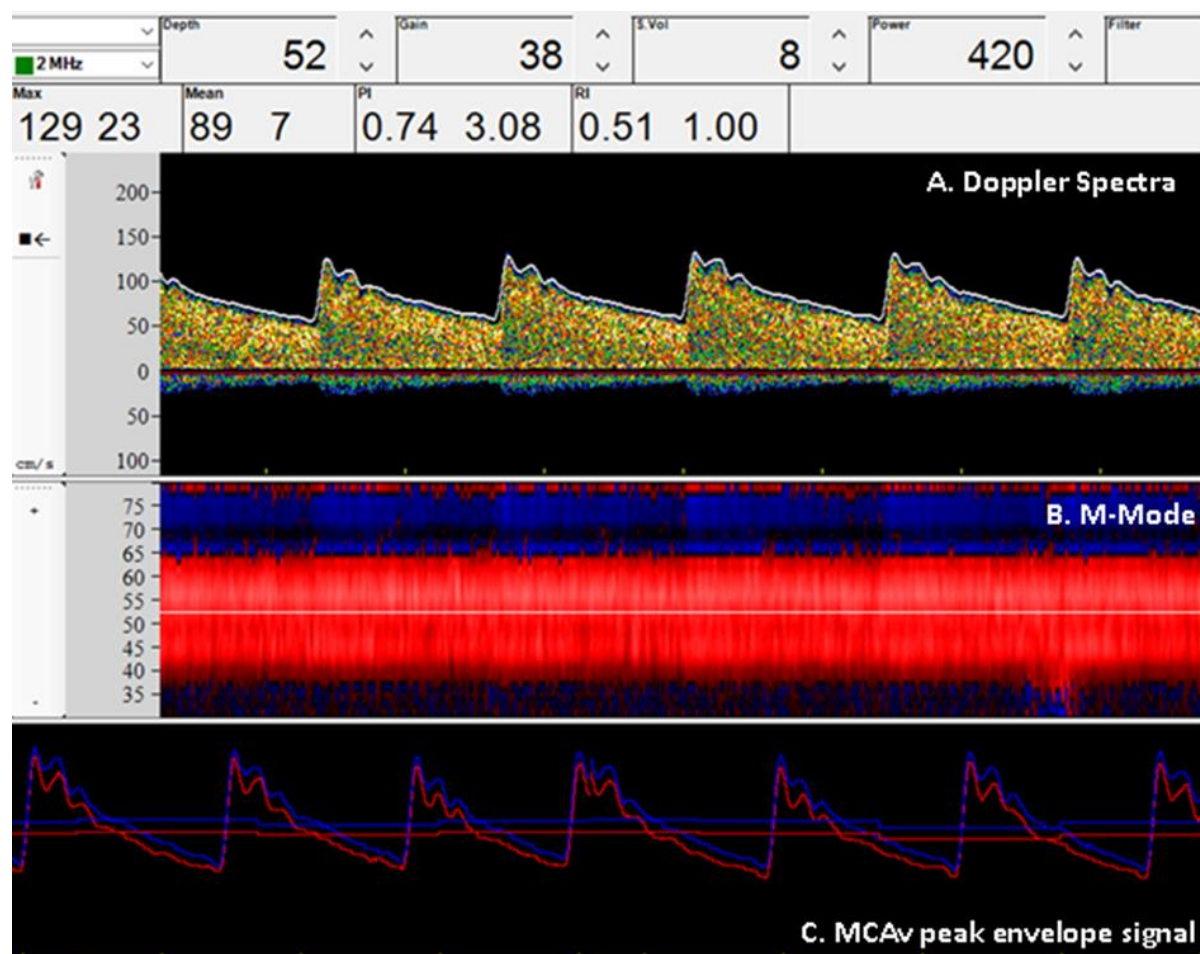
The right middle cerebral artery (MCA) is insonated with the transcranial Doppler ultrasound (TCD) probe. A: The Doppler spectrogram produced by the TCD B: M-mode Doppler. C: MCA peak envelope signal which can be exported for offline analysis (n = 1).
